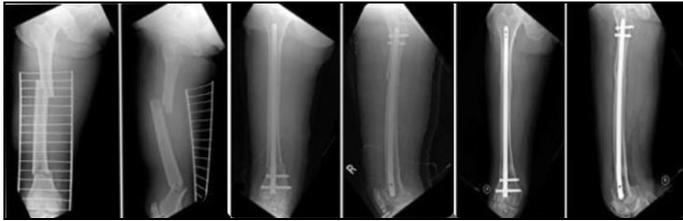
Showing pre-operative, immediate post-operative and 15 months followup Xray of patient operated by Antegrade nailing
